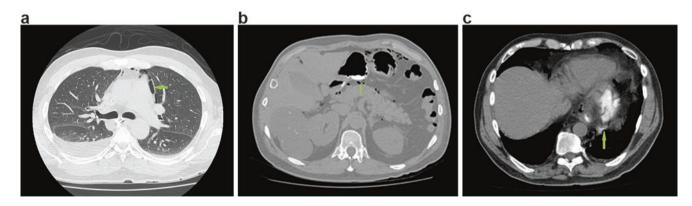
(a) Post-procedure CT esophagram showing pneumomediastinum, (b) pneumoperitoneum, and (c) leak of oral contrast indicating perforation
